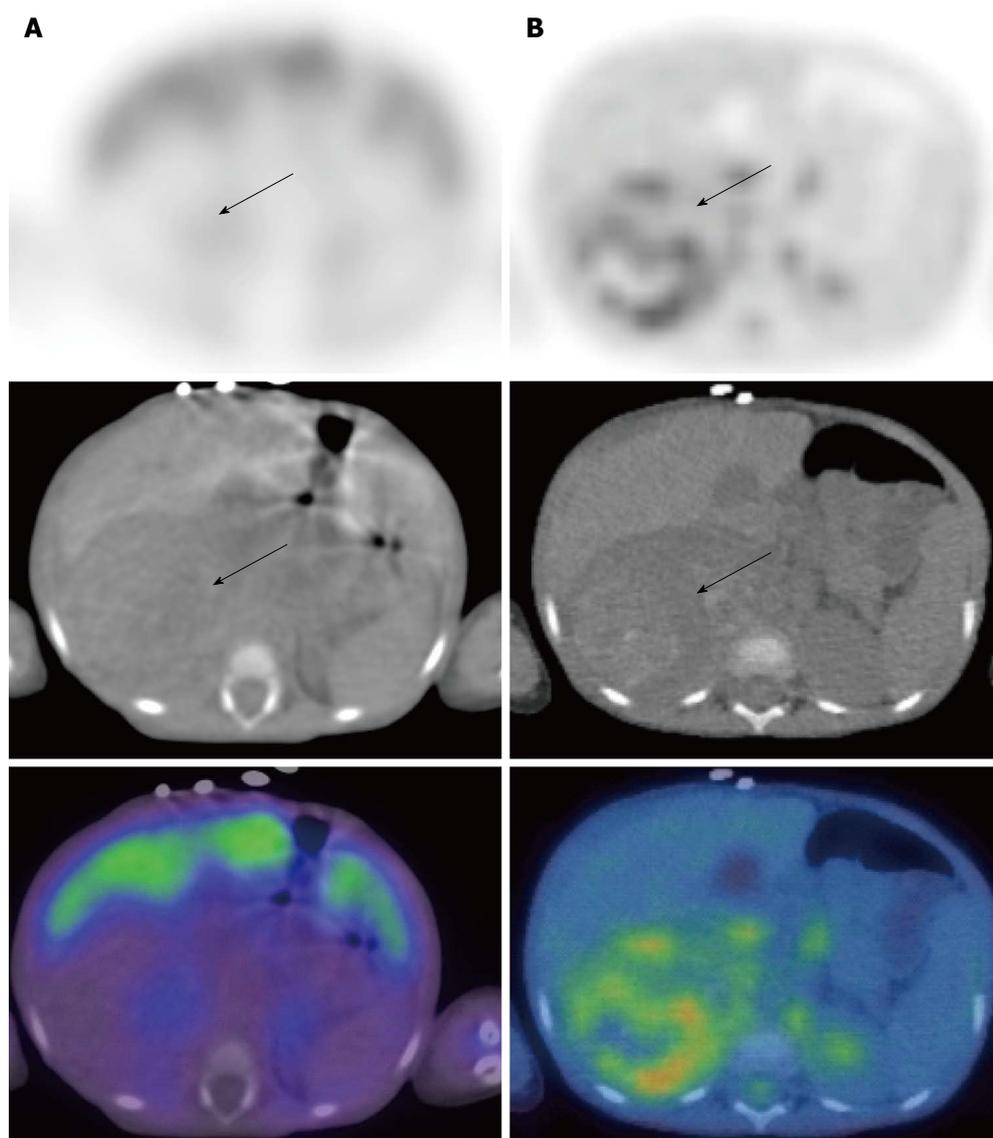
Neuroblastoma in a 2-year-old female. ^{123}I -metaiodobenzylguanidine (MIBG) single positron emission tomography/computed tomography (SPECT/CT) images (A) demonstrated a large right suprarenal mass displacing the organs which was not MIBG-avid (arrows). FDG PET/CT (B) showed moderate heterogeneous metabolic activity within the mass. PET/CT: Positron emission tomography/computed tomography; FDG: 2-deoxy-2-(^{18}F)fluoro-D-glucose.
